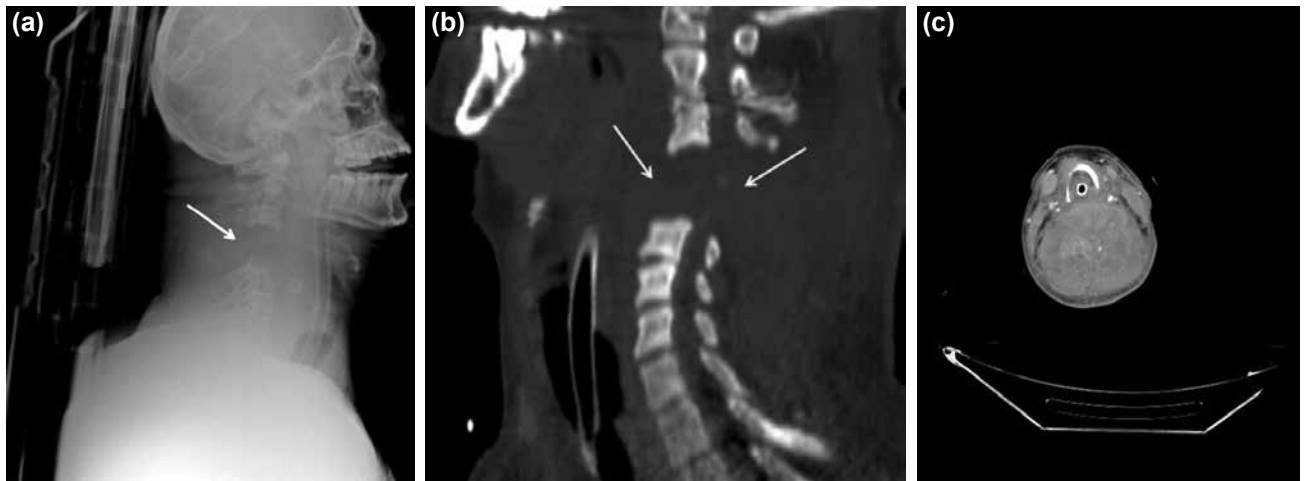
(a) Lateral cervical radiography reveals the distraction of C3-4 and craniocaudal displacement, separation (arrow). (b) Cervical sagittal reformat image shows distraction of C3-4 and craniocaudal displacement, widening of the space between C3 and C4 (arrows) because of the hematoma without fracture. (c) The axial CT image of the hematoma (curved arrow) between C3 and C4, and slight hyperdensities represent active extravasation from microvasculars.
